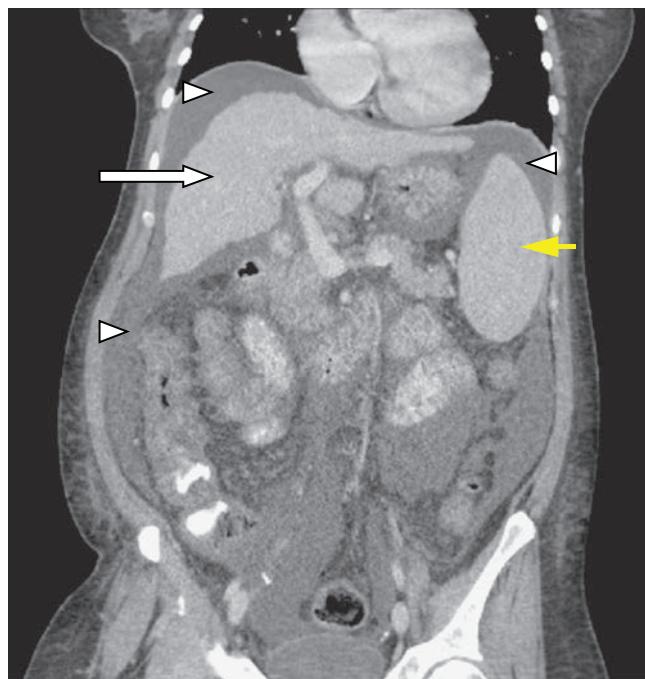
CT of a patient with a cirrhotic, nodular liver (white arrow), splenomegaly (yellow arrow), and ascites (arrowheads).
